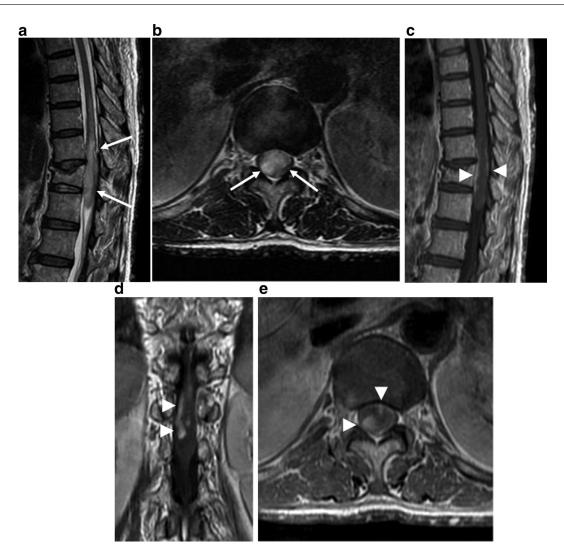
A 69-year-old male with NF1. MRI of the lumbar spine 6 months later the first admission. (A) Sagittal T2WI, (b) transverse T2WI, (c) sagittal contrast-enhanced T1WI, (d) coronal contrast-enhanced T1WI, and (e) transverse contrast-enhanced T1WI. There is a decrease in the height of T12 vertebral body without a significant interval change. A healed compression fracture of Th12 is found. Spinal cord swelling with intramedullary edematous change at the levels of T9 through L1 is again found on sagittal and transverse T2WI (arrows), which may increase in size compared to the previous MRI 6 months before. Relatively strong enhancement predominantly at the periphery of the swollen spinal cord at the levels of T11 through L1 on sagittal, coronal, and transverse contrast-enhanced T1WI (arrow heads). Therefore, primary or metastatic spinal cord tumors are suspected.
